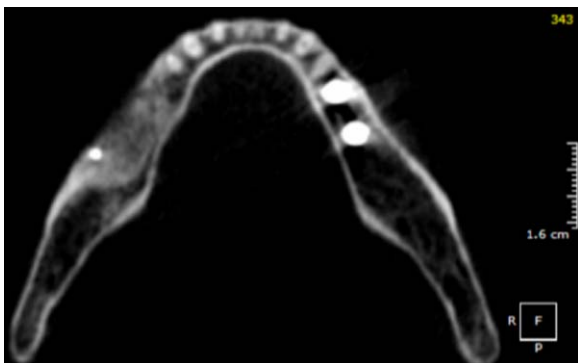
CBCT Scan after horizontal augmentation.
